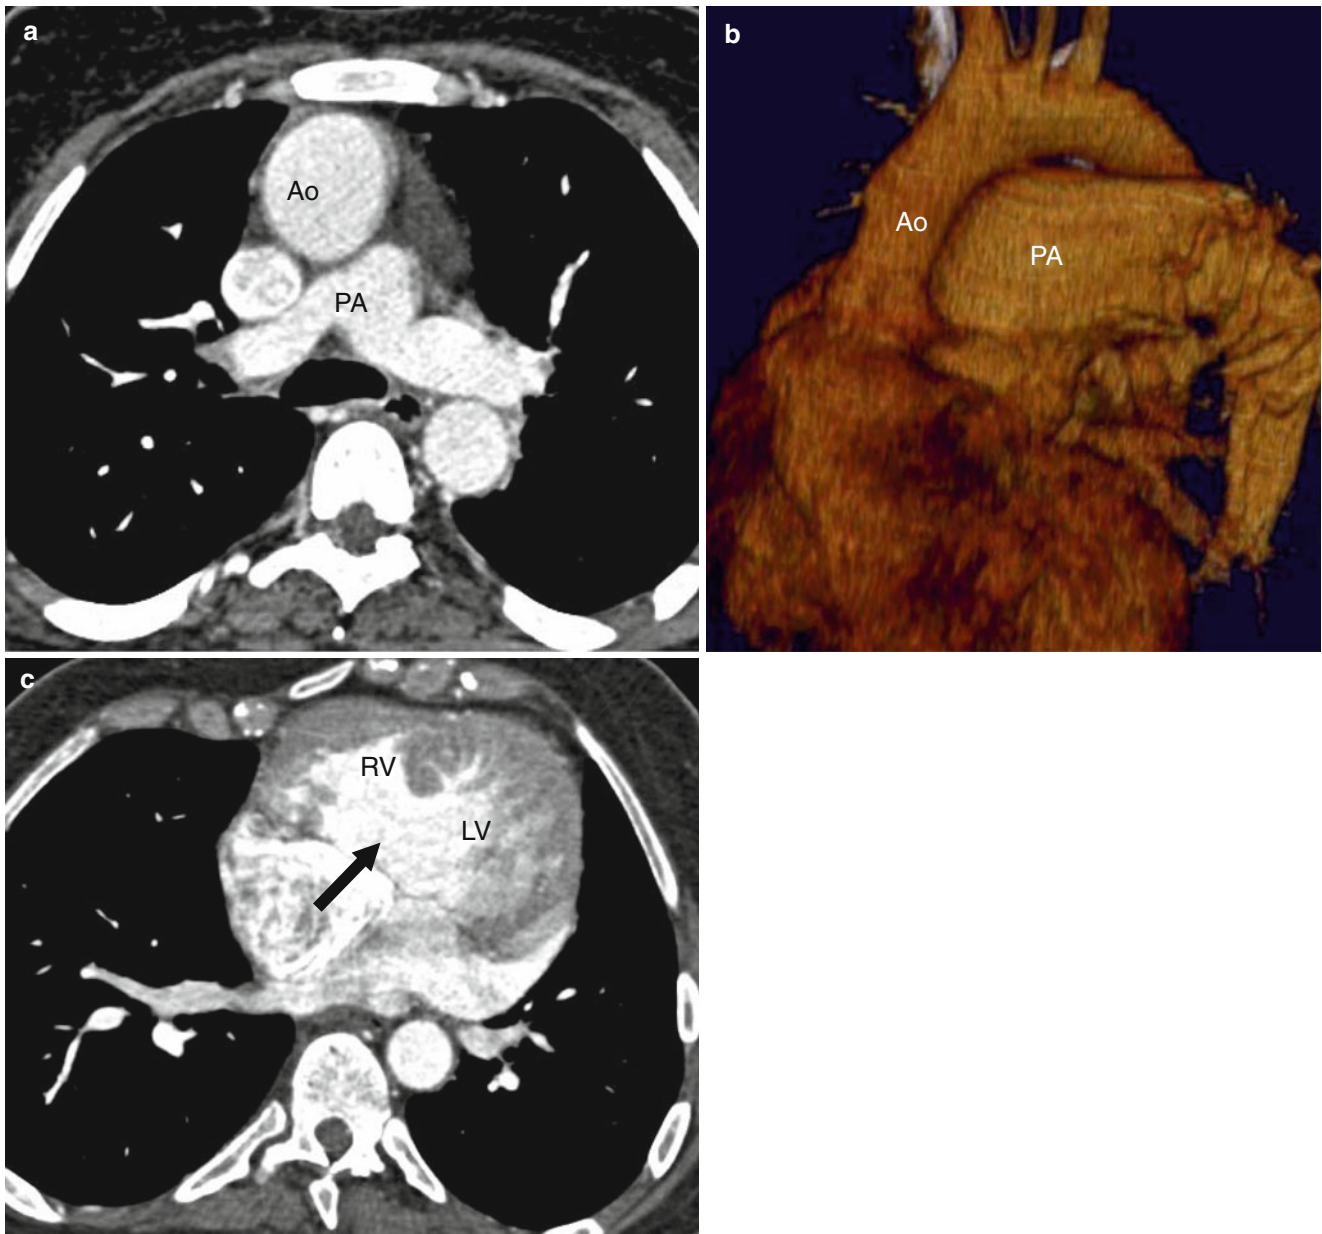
Uncorrected transposition of the great arteries. A 54-year-old woman with a right sided Blalock–Taussig and no further surgery. A computed tomogram was performed to evaluate for possible Eisenmenger physiology. Panel (a) is an axial cut and panel (b) is an
